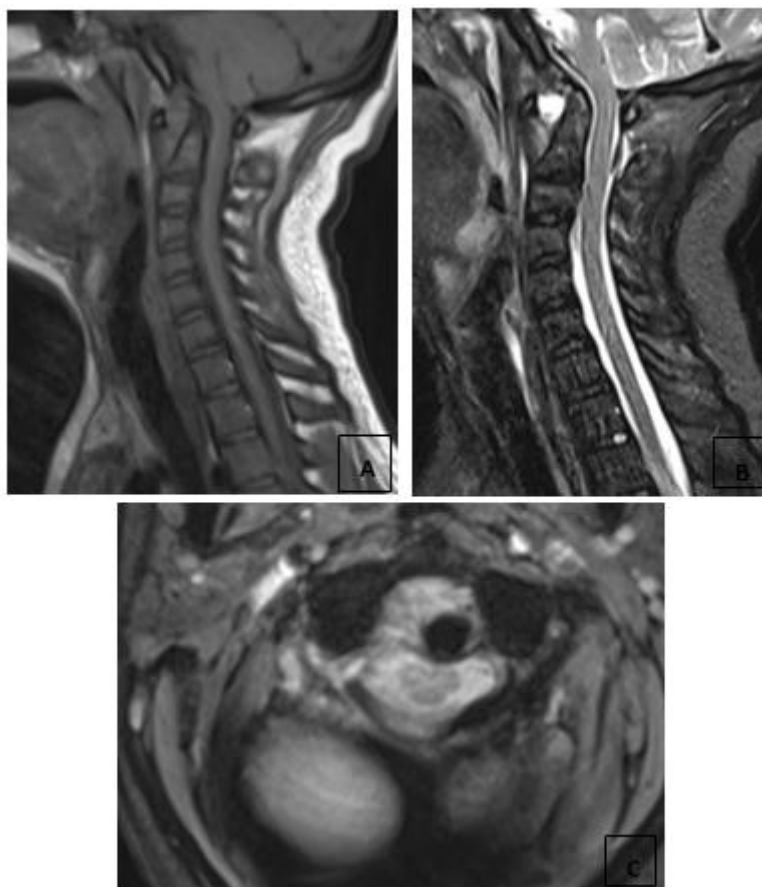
Cervical spine MRI in sagittal T1, sagittal T2, and axial T2-weighted images (A, B, C) showing C1–C2 posterior displacement of the odontoid process which compresses the transverse ligament, that appears thickened and stretched, along with a focal T2 hyperintensity on its left portion. The bony spinal canal is narrowed at this level (minimal diameter: 8 mm), without spinal cord signal abnormality
